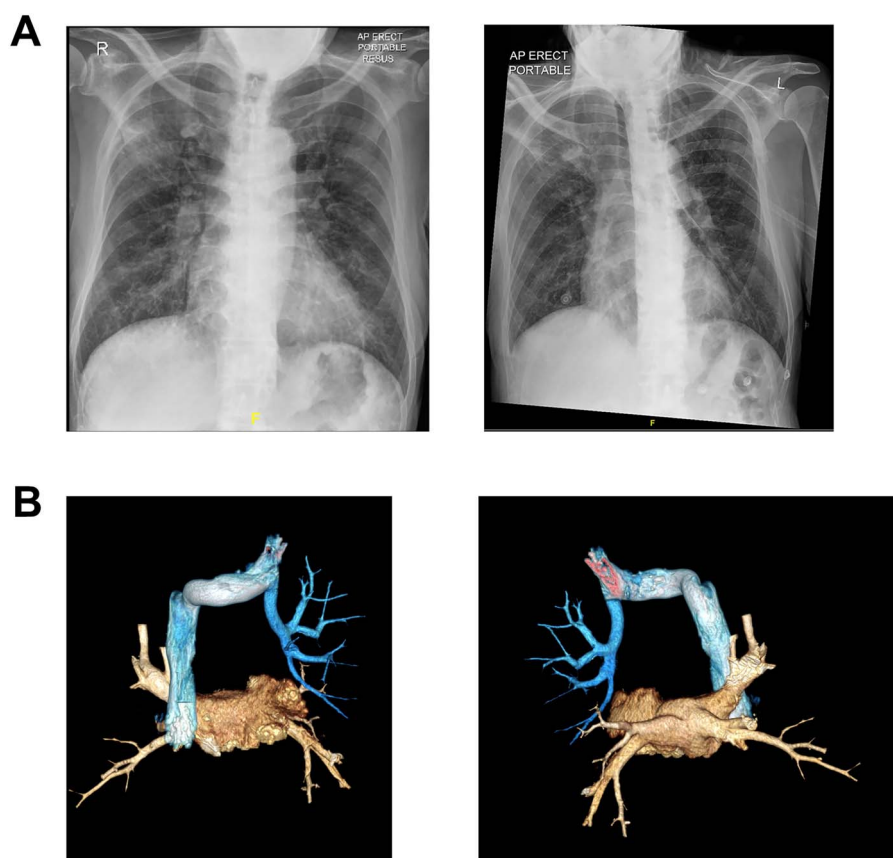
Incidental PAPVR identified on central venous cannulation. (A) Initial CXR (left); Post-CVC placement CXR showing inadvertent cannulation of anomalous left pulmonary vein (right). (B) CTPA (with CT 3D reconstruction) showing left-sided partial anomalous pulmonary venous return anterior view (left); posterior view (right).
